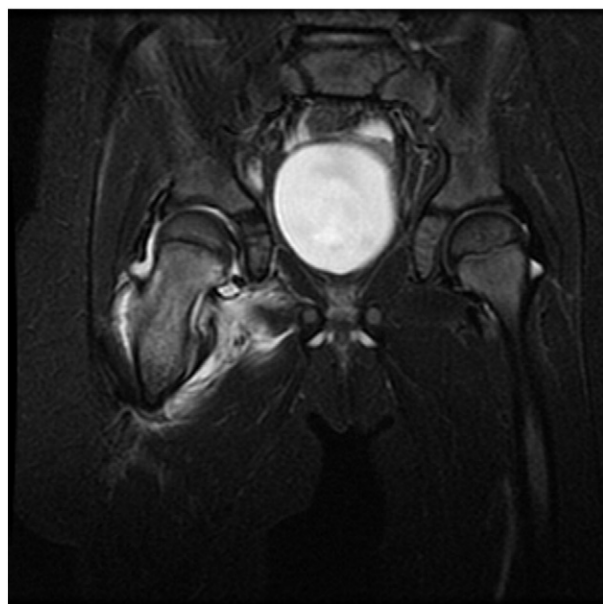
Magnetic resonance imaging of a patient with a right-sided septic hip joint. Short T1 inversion recovery. The image showed a moderate right hip effusion as well as bone marrow edema and surrounding myositis.
